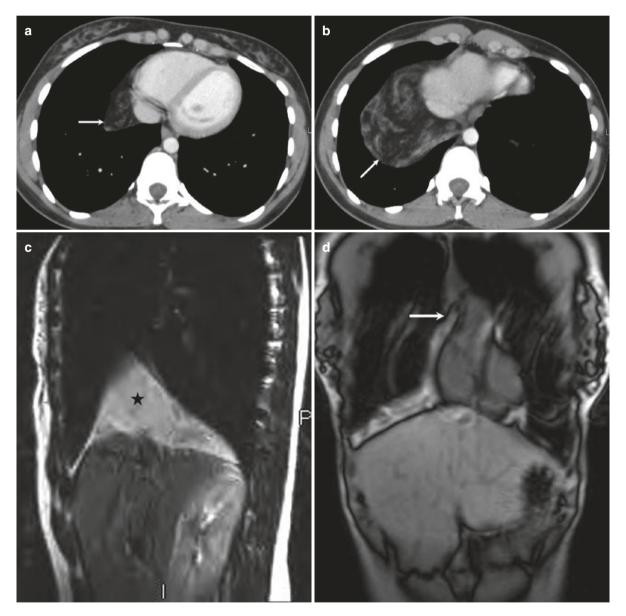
Large thymolipoma in the inferior compartment of anterior mediastinum abutting the diaphragm. (a, b) Axial CT images show a well-circumscribed fat density mass (arrow) with whorls of soft tissue adjacent to the heart with larger component inferiorly.
